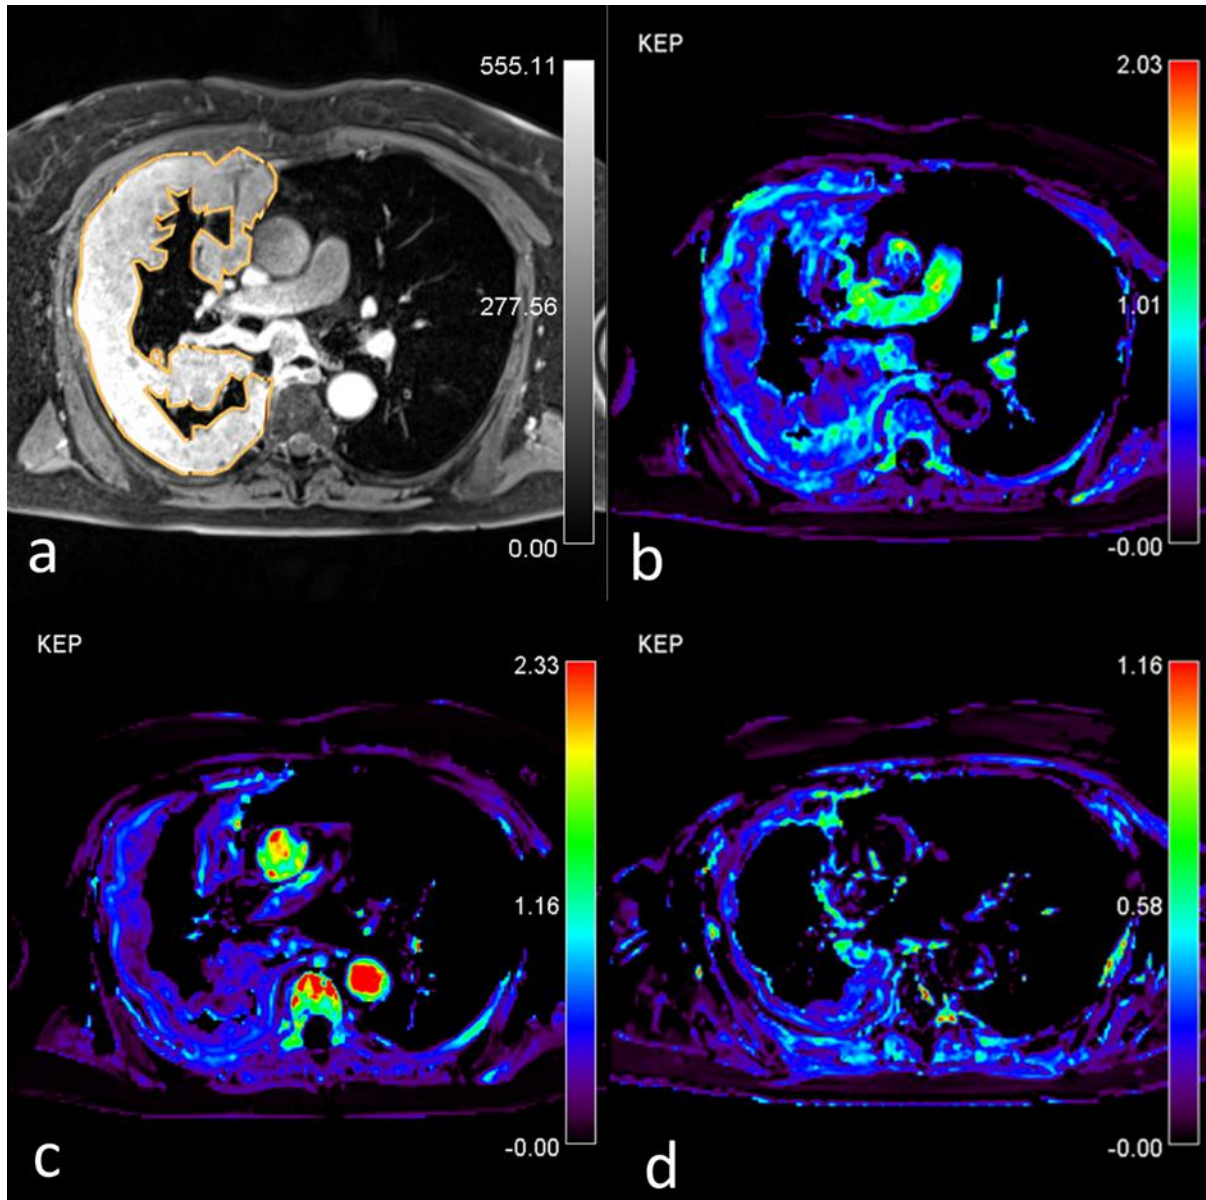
Patient with partial response. a) Post-contrast T1-weighted turbo-FLASH. Source image shows the region of interest (ROI) drawn around the tumor, AATH-calculated k_{ep} parametric map (1/min) from b) pre-treatment, c) intra-treatment, and d) post-treatment study is shown. Tumor reduced in size which was followed by a reduction in the k_{ep} during the course of chemotherapy. The distribution of the k_{ep} is spatially heterogeneous with high values in the periphery and low values in the core.
